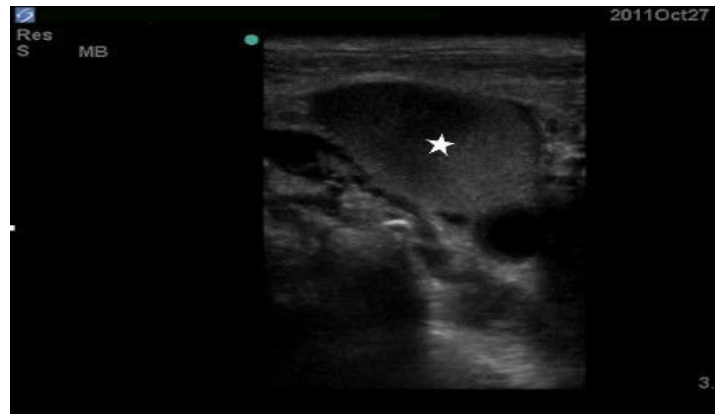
Ultrasound image demonstrating clot in right IJ (star). IJ, internal jugular
